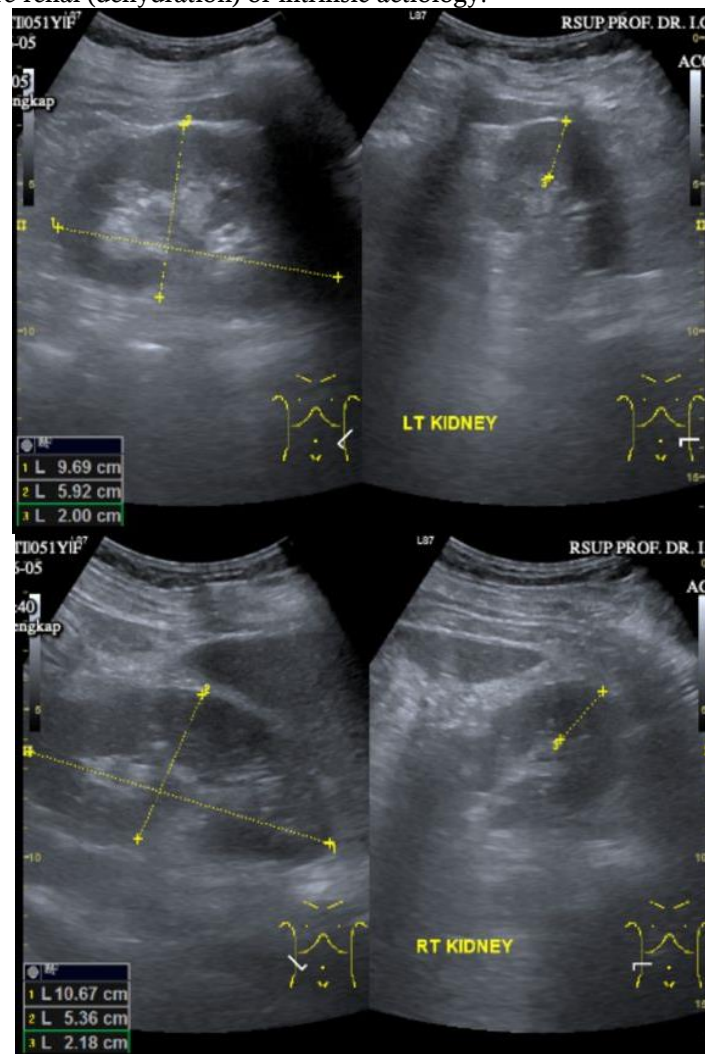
Abdominal Ultrasound
